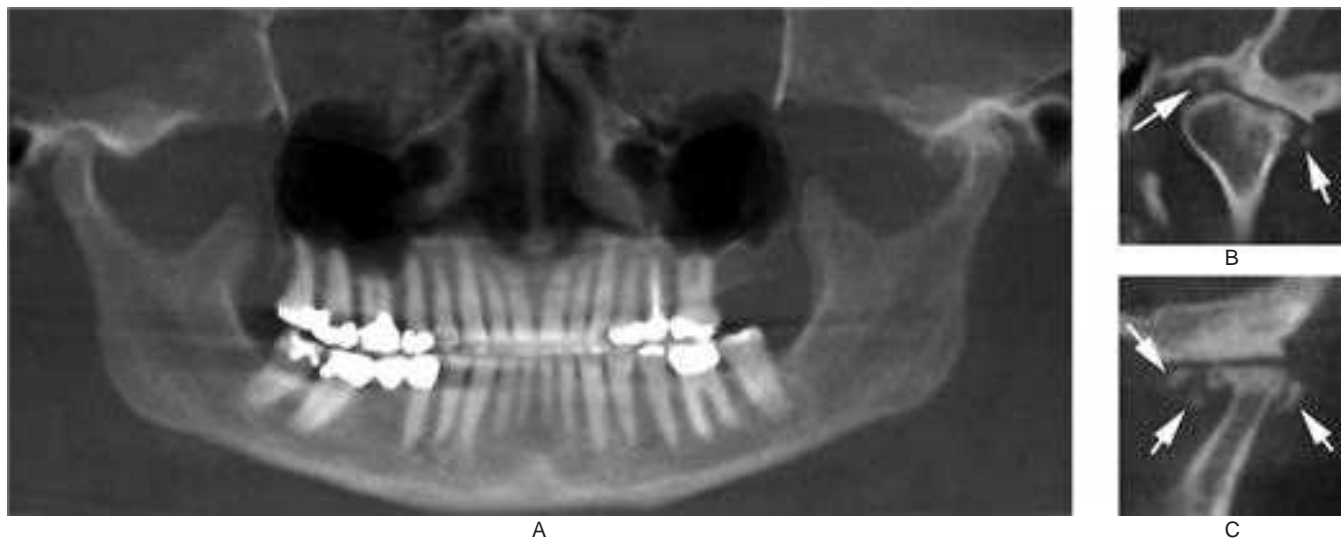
Synovial chondromatosis of the left temporomandibular joint as shown in a cone beam computed tomography.
